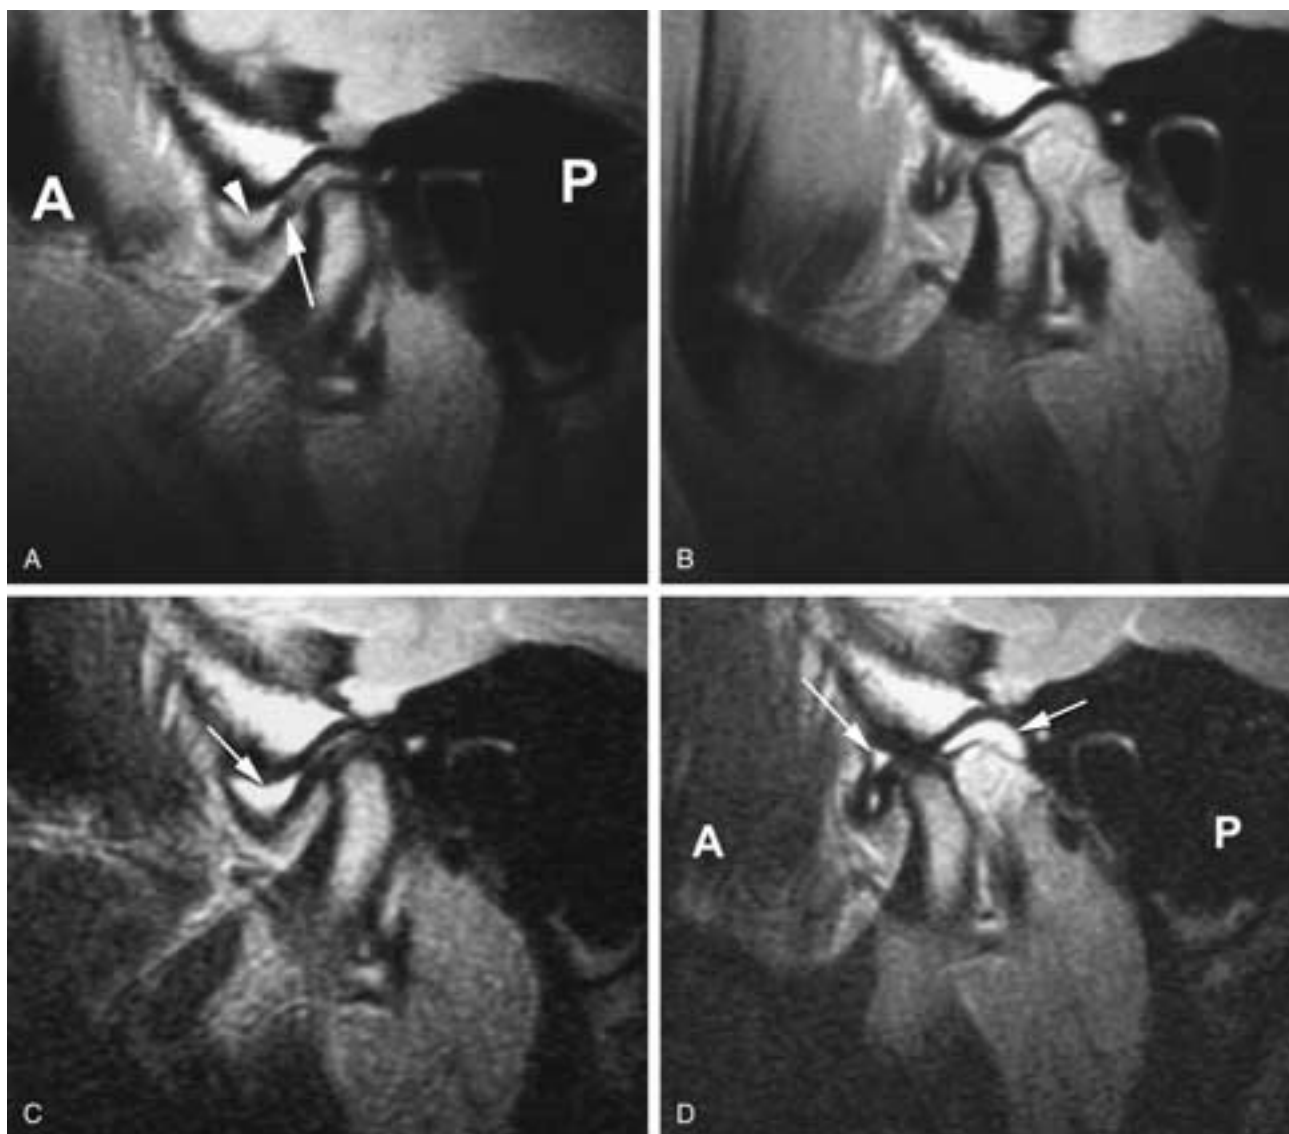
Large amount of joint fluid (effusion) in a painful joint. Closed lock (anterior displacement without recapture). A, Proton density image. The disk is completely dislocated anteriorly in the closed-mouth position. The fluid (*arrowhead*) in the upper joint compartment can be appreciated even on the proton density image. Posterior thick band (*arrow*). B, Open-mouth position, proton density image. The condyle pushes the disk anteriorly but does not recapture. The disk is deformed. C, T2-weighted image, closed-mouth position. The bright fluid (*arrow*) in the upper compartment of the joint is easily appreciated. D, Open-mouth position. The fluid in the joint (*arrows*) is more clearly seen on the T2-weighted image. Anteriorly, the fluid outlines the upper contour of the disk. Posteriorly, the fluid outlines the superior surface of the bilaminar folds (retrodiskal tissues). *A*, anterior; *P*, posterior.
